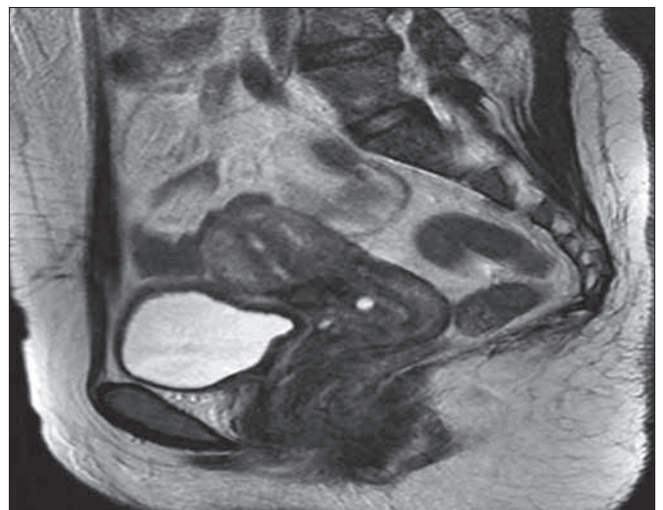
MRI image after the treatment. The T2-weighted contrast-enhanced sagittal plane cross-section image after methotrexate treatment of the uterine corpus shows significant reductions in the sizes of the lesions.
